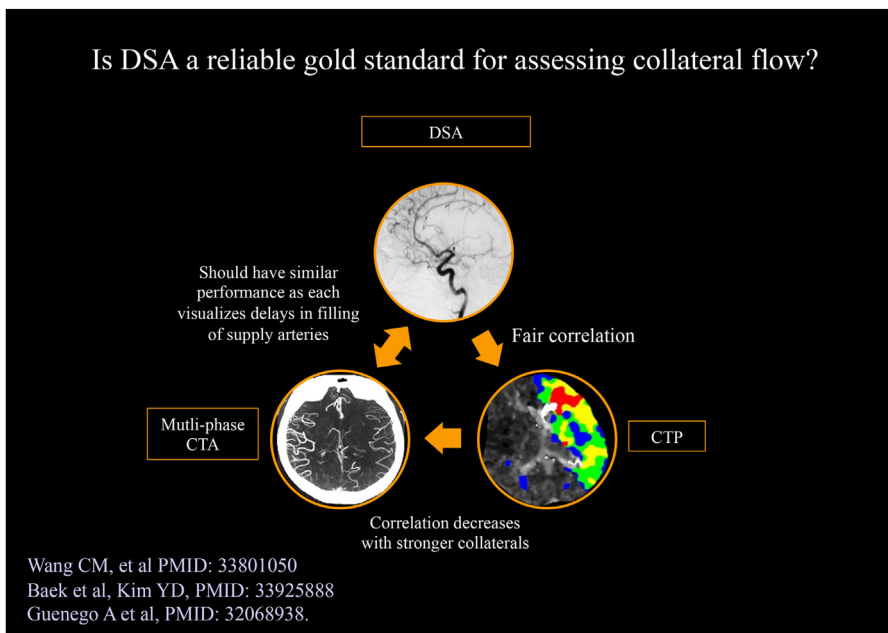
DSA and CTA are subjective assessments prone to variance based on rater differences. CTP is objective and quantitative but has become dependent on timing metrics. By comparison, the fundamental flow metrics that compose the “Central Volume Principle” $CBV = CBF \times MTT$ have surprisingly shown limited clinical utility.
